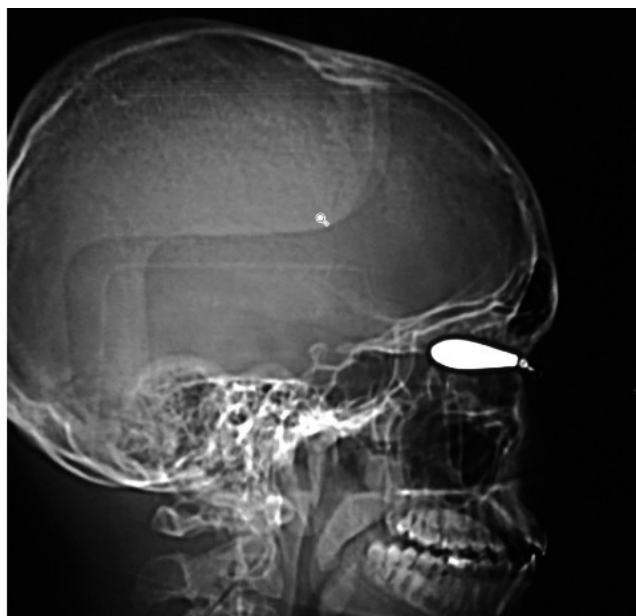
Lateral X-ray of skull. Foreign body visible in the orbital projection
